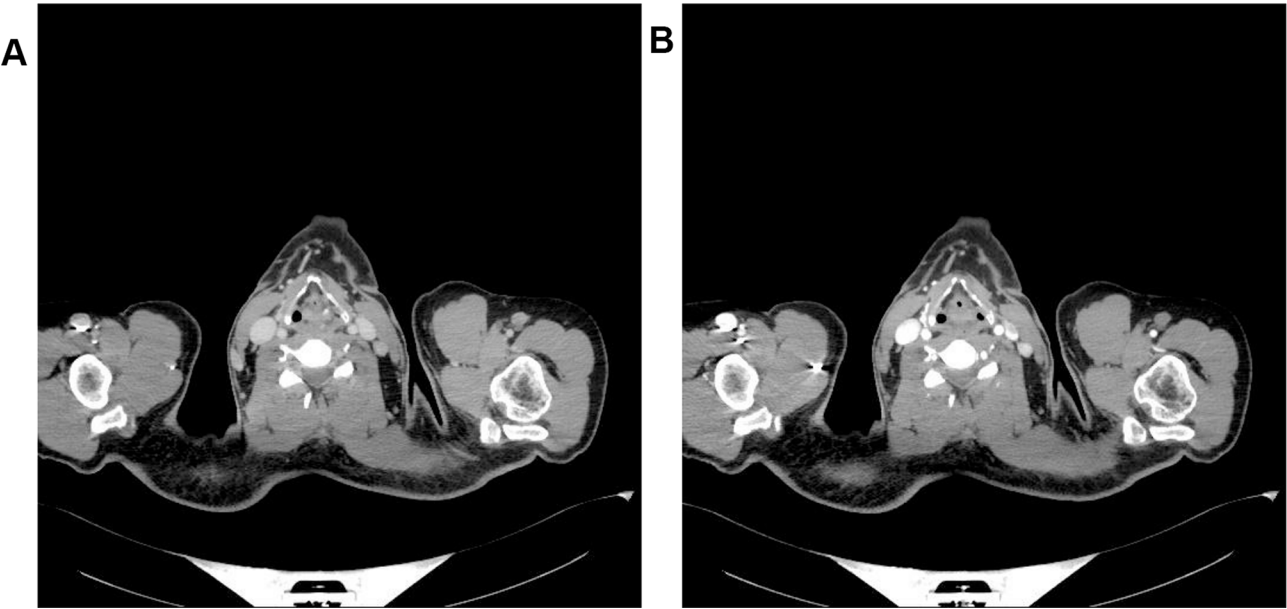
Computerized Tomography (CT) imaging showed multiple swollen lymph nodes on the left side of the neck, partially enhanced during the enhancement phase
